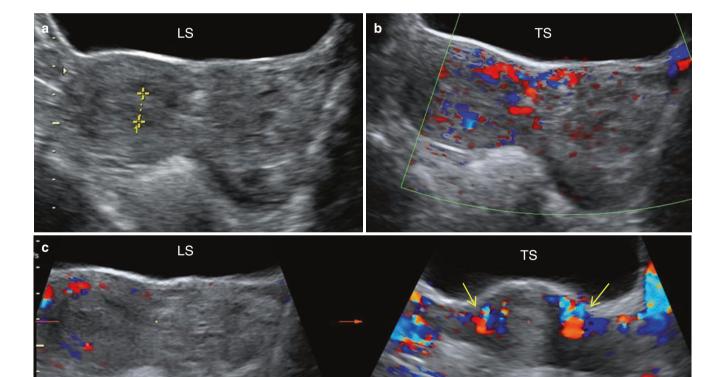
Cervical ectopic pregnancy. Patient presented with spotting and a positive pregnancy test. (a) 'Hourglass'-shaped uterus noted, with a ballooned-out cervix. The cervix appeared heterogeneous and hyperechoic. Endometrial cavity was empty. (b) No significant flow seen on Doppler in the cervix. (c) On 3D Doppler, multiplanar sectional views revealed that the entire complex mass was below the level of the closed internal os (i.e. the level at which the uterine arteries (*arrows*) approach the uterus transversely, seen in the image on the right). The internal os was closed, which helped in making a diagnosis of a cervical ectopic pregnancy
